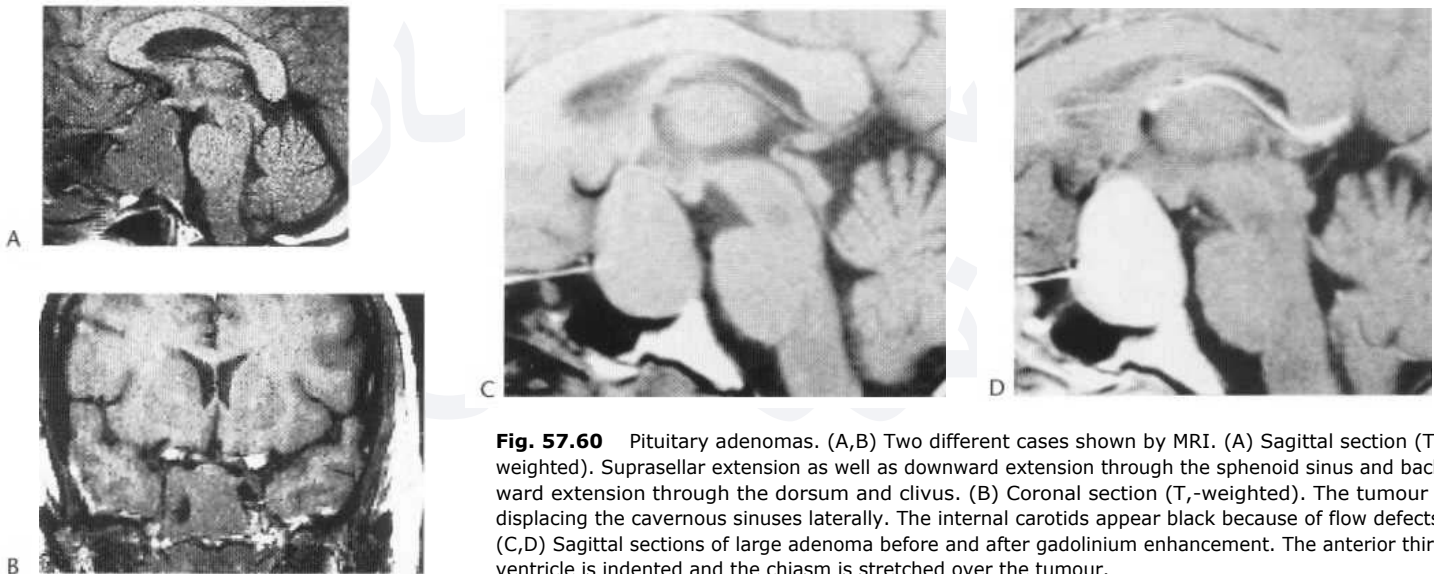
Pituitary adenomas. (A,B) Two different cases shown by MRI. (A) Sagittal section (T_1 -weighted). Suprasellar extension as well as downward extension through the sphenoid sinus and backward extension through the dorsum and clivus. (B) Coronal section (T_1 -weighted). The tumour is displacing the cavernous sinuses laterally. The internal carotids appear black because of flow defects. (C,D) Sagittal sections of large adenoma before and after gadolinium enhancement. The anterior third ventricle is indented and the chiasm is stretched over the tumour.
